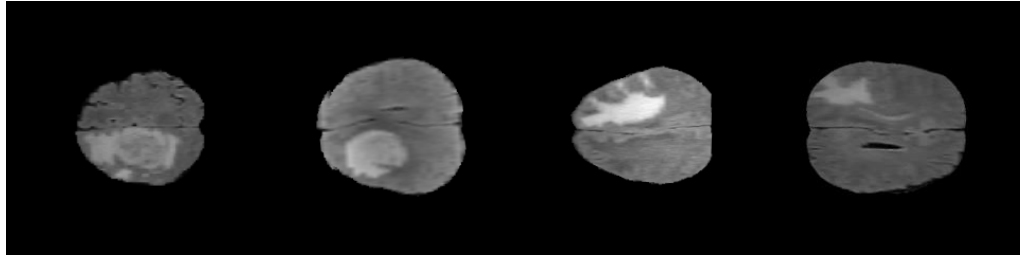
Sample MRI images with tumor
